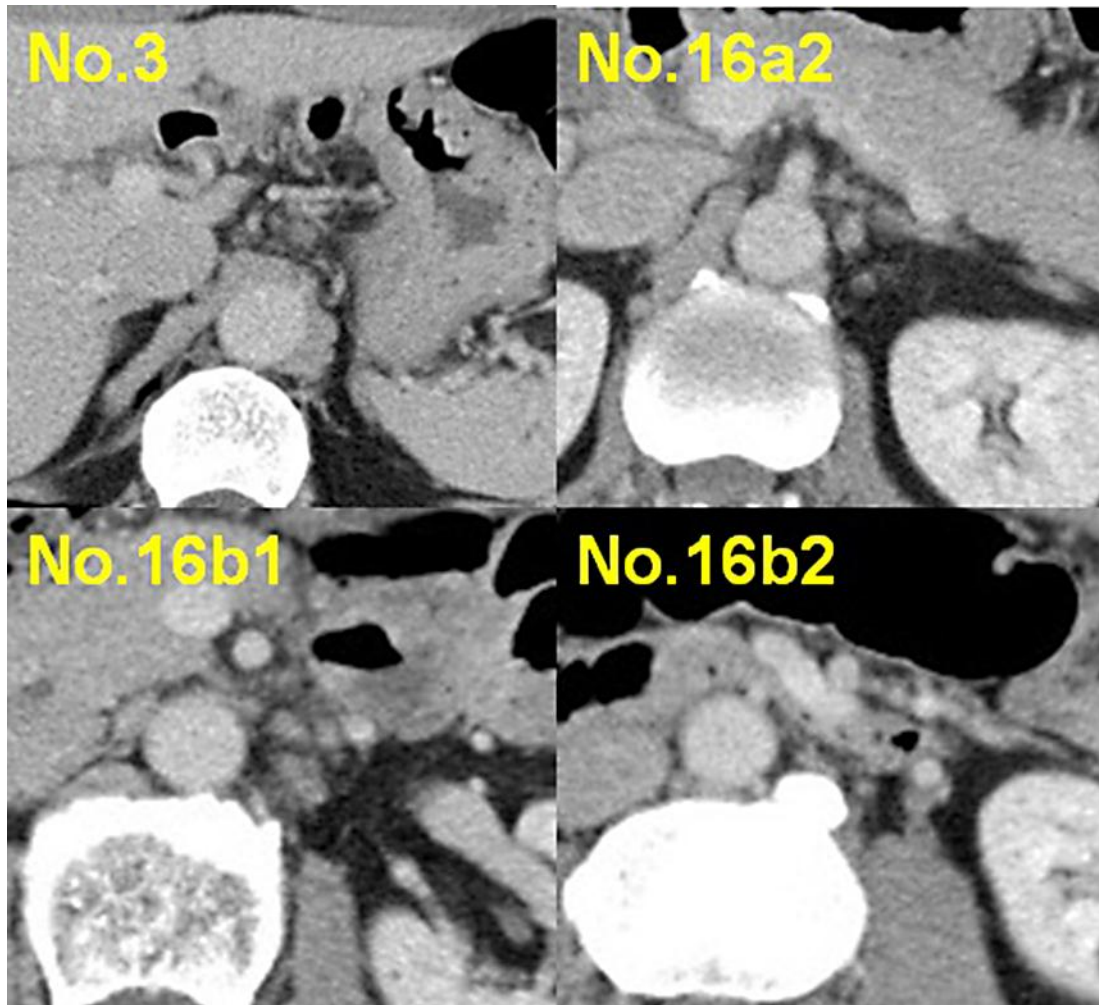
CT imaging at the initial visit. CT images revealed enlargement of the regional lymph nodes and PAN extending from the caudal side of the celiac artery to the caudal side of the inferior mesenteric artery.
